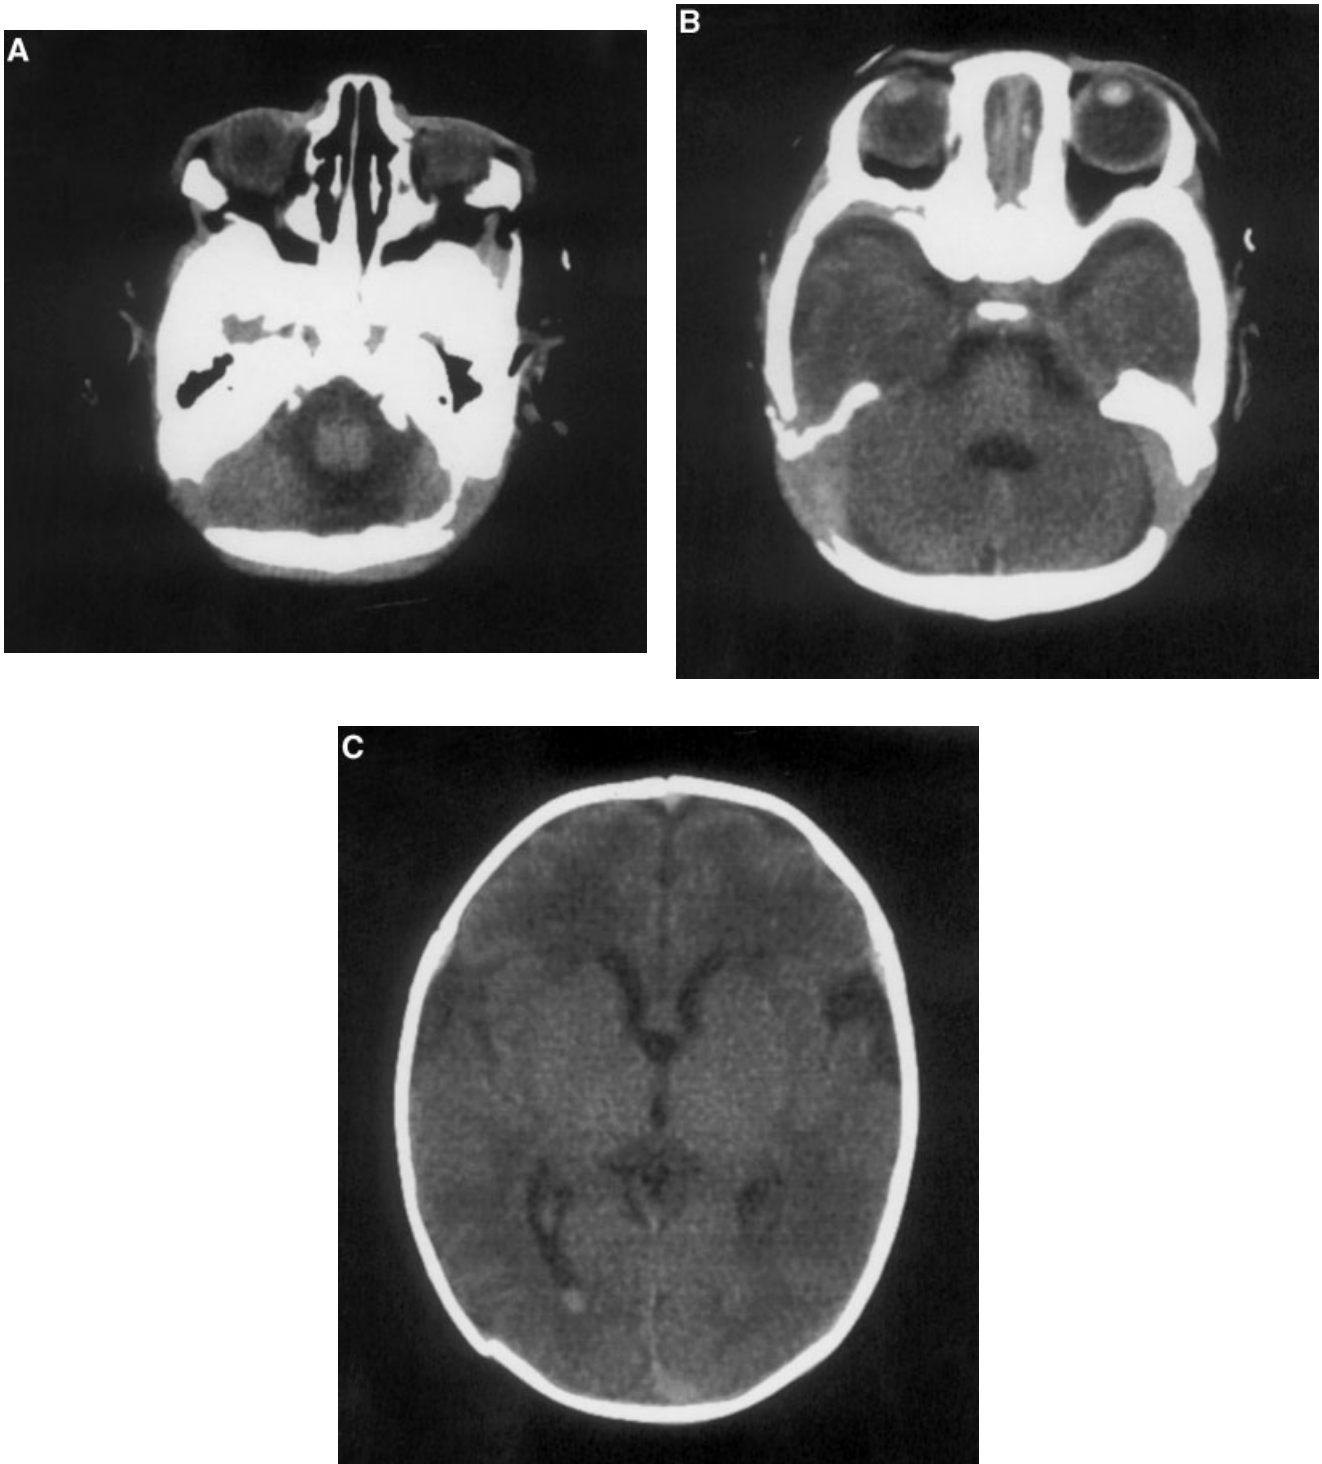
(Hospital Day 22). CT of the brain without contrast. Near complete resolution of the left occipital subdural hematoma and tentorial hematomas (A,B). Decreased parenchymal edema (C).
